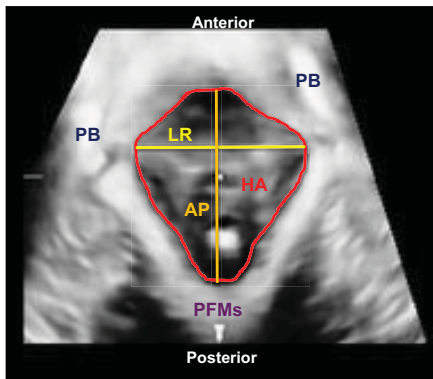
Representative ultrasound image of intact pelvic floor muscles with biometry indicated. LR = left-right diameter; AP = anteroposterior diameter; HA = hiatal area; PFMs = pelvic floor muscles; PB = pubic bone [3].
